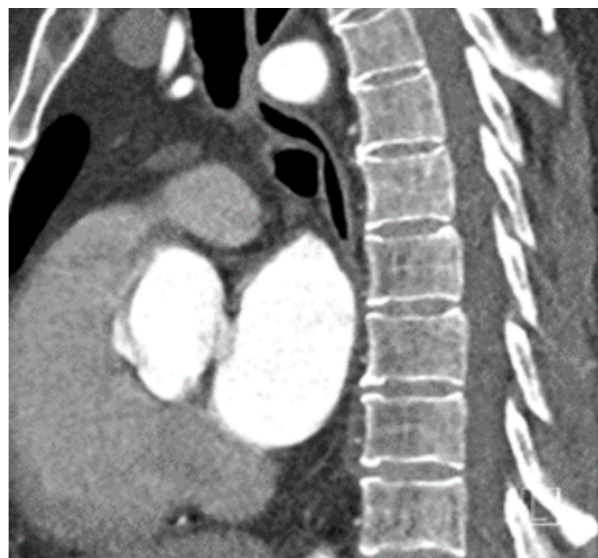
Sagittal CT image in the arterial phase showing the narrowing of the trachea and esophagus due to the course of the aorta.
